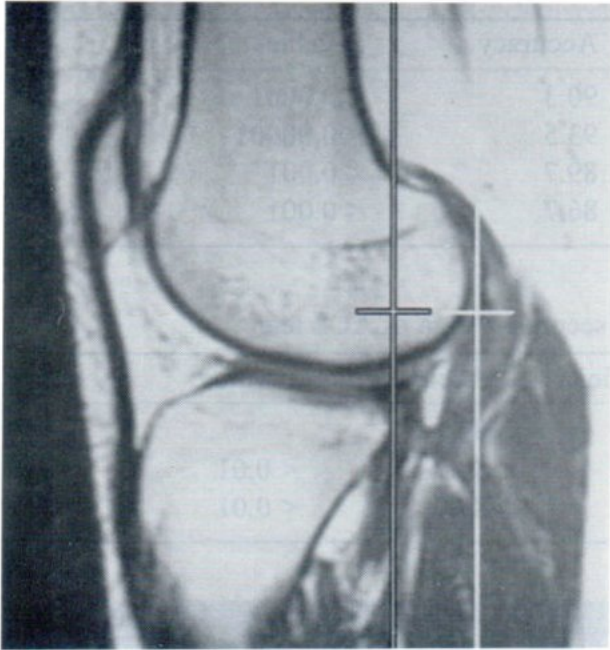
Anterior translation of tibia. On sagittal T1-weighted MR image, the vertical lines drawn tangent to the posterior cortex of lateral femoral condyle and posterior cortex of lateral tibial plateau are 21 mm apart in this case, definitive for complete ACL tear which was confirmed by arthroscopy.
